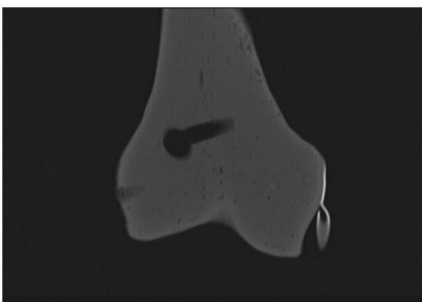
Coronal CT of trans-tibial sample with tunnel convergence.
